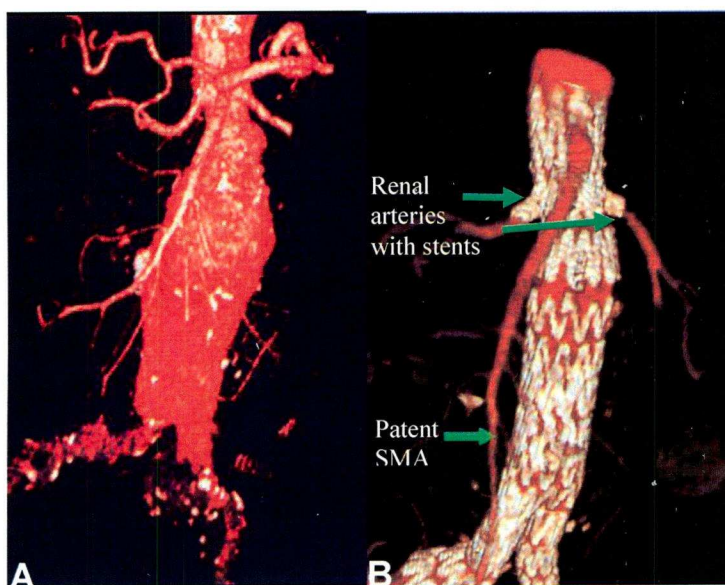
Three-dimensional computed tomographic reconstructions of a juxtarenal abdominal aortic aneurysm (A) before and (B) after fenestrated endovascular aneurysm repair.
